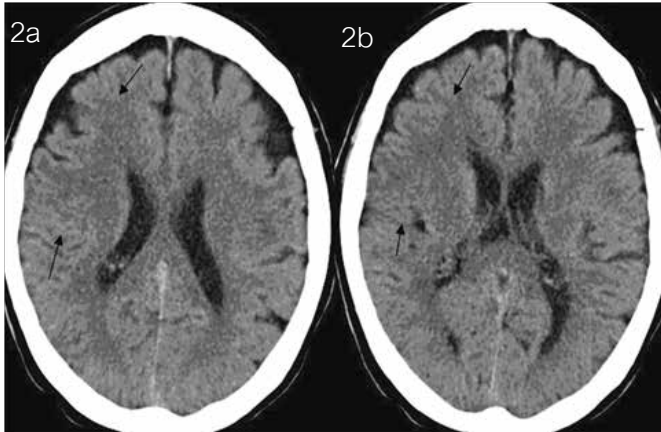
Axial CT images of 76-year-old female with left sided weakness
